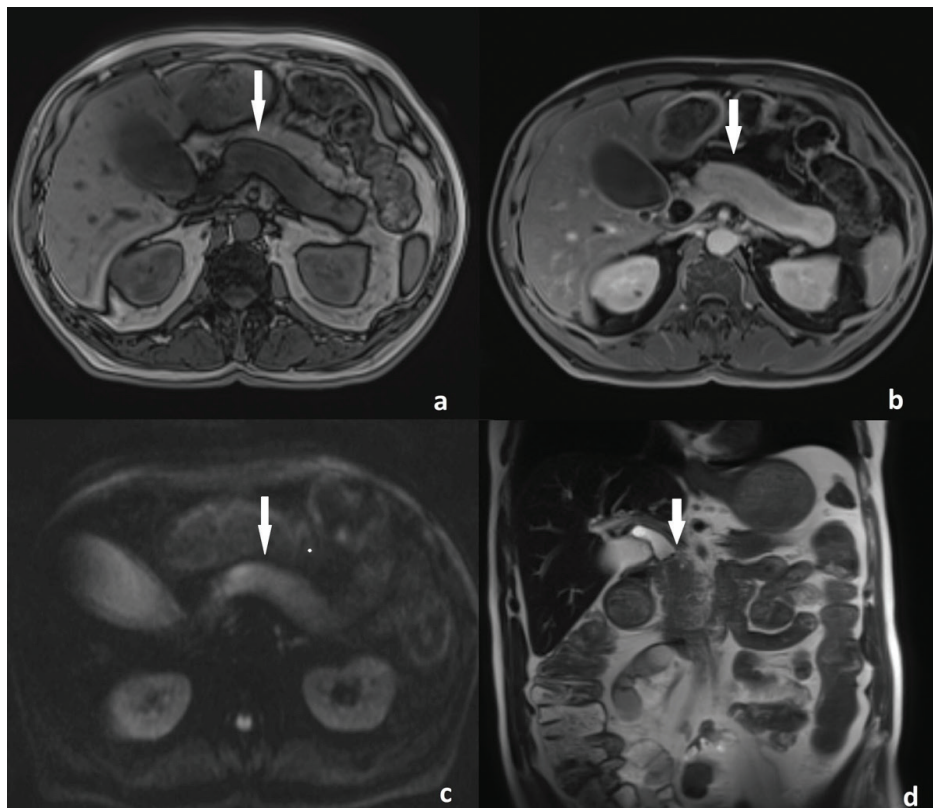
Axial T1 out of phase image (1a) demonstrates diffuse enlargement of the pancreas with smooth contours and decreased T1 signal intensity (arrow). Post-contrast axial T1-weighted image (1b) shows homogeneous enhancement of the pancreas (arrow). The axial diffusion-weighted image ($b=1500 \text{ s/mm}^2$) (1c) reveals a uniform diffusion hyperintensity consistent with inflammatory activity (arrow). Coronal T2-weighted image (1d) demonstrates upstream dilatation of the common bile duct proximal to its intrapancreatic segment (arrow)
